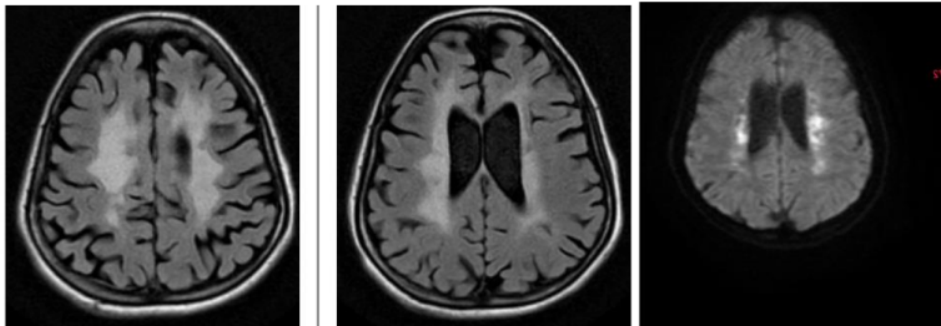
MRI Brain shows confluent T2/FLAIR hyperintensities with DWI restriction are noted predominantly involving the periventricular white matter of bilateral frontal and parietal lobes.
